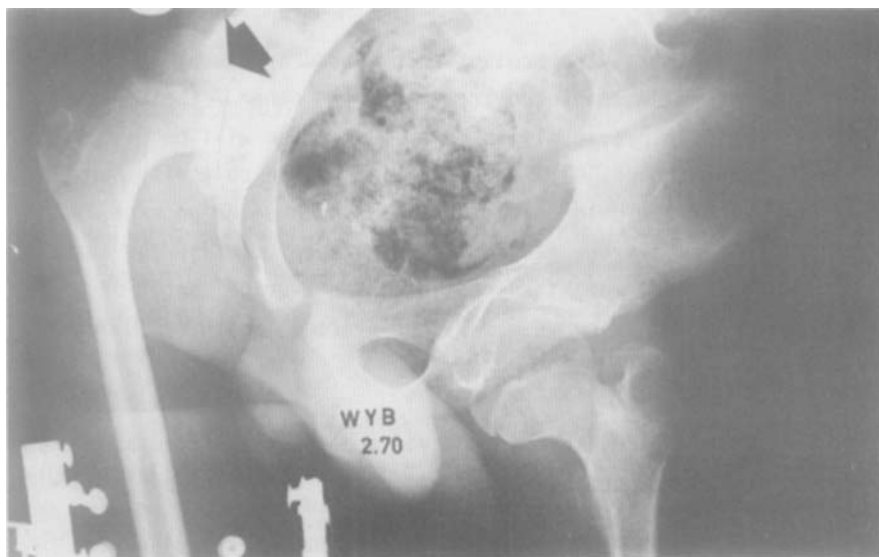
a. Pre-operative standing radiograph. Note the dislocating right hip joint (arrow) associated with the pelvic obliquity.
